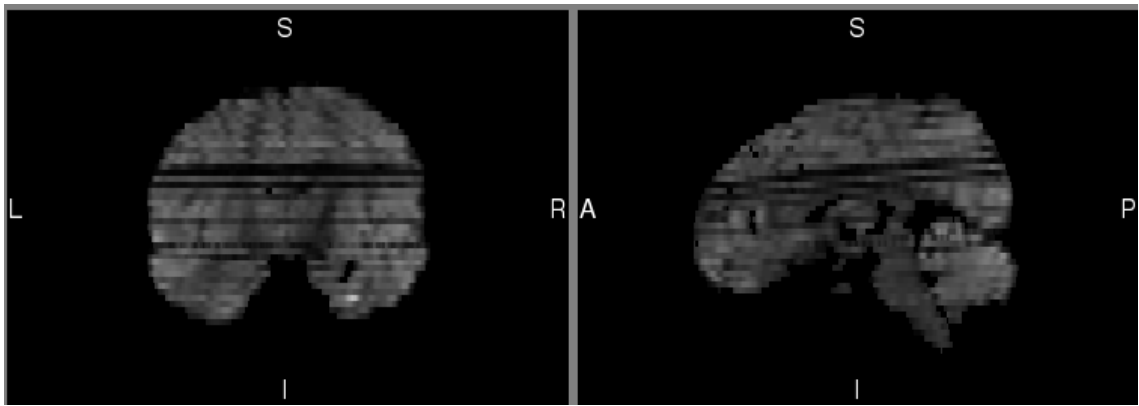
Inter-slice and intra-slice intensity artefact in sagittal and coronal planes of DWI data. LR (left-right), SI (superior-inferior), AP (anterior-posterior).
